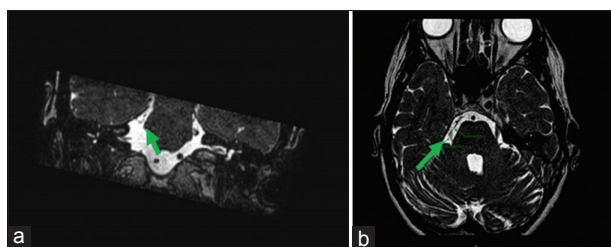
(a) Coronal magnetic resonance imaging T2W VISTA showing hypoplastic trigeminal nerve, touched by a pontine artery in the pre-pontine cistern (green arrows); (b) Axial view
